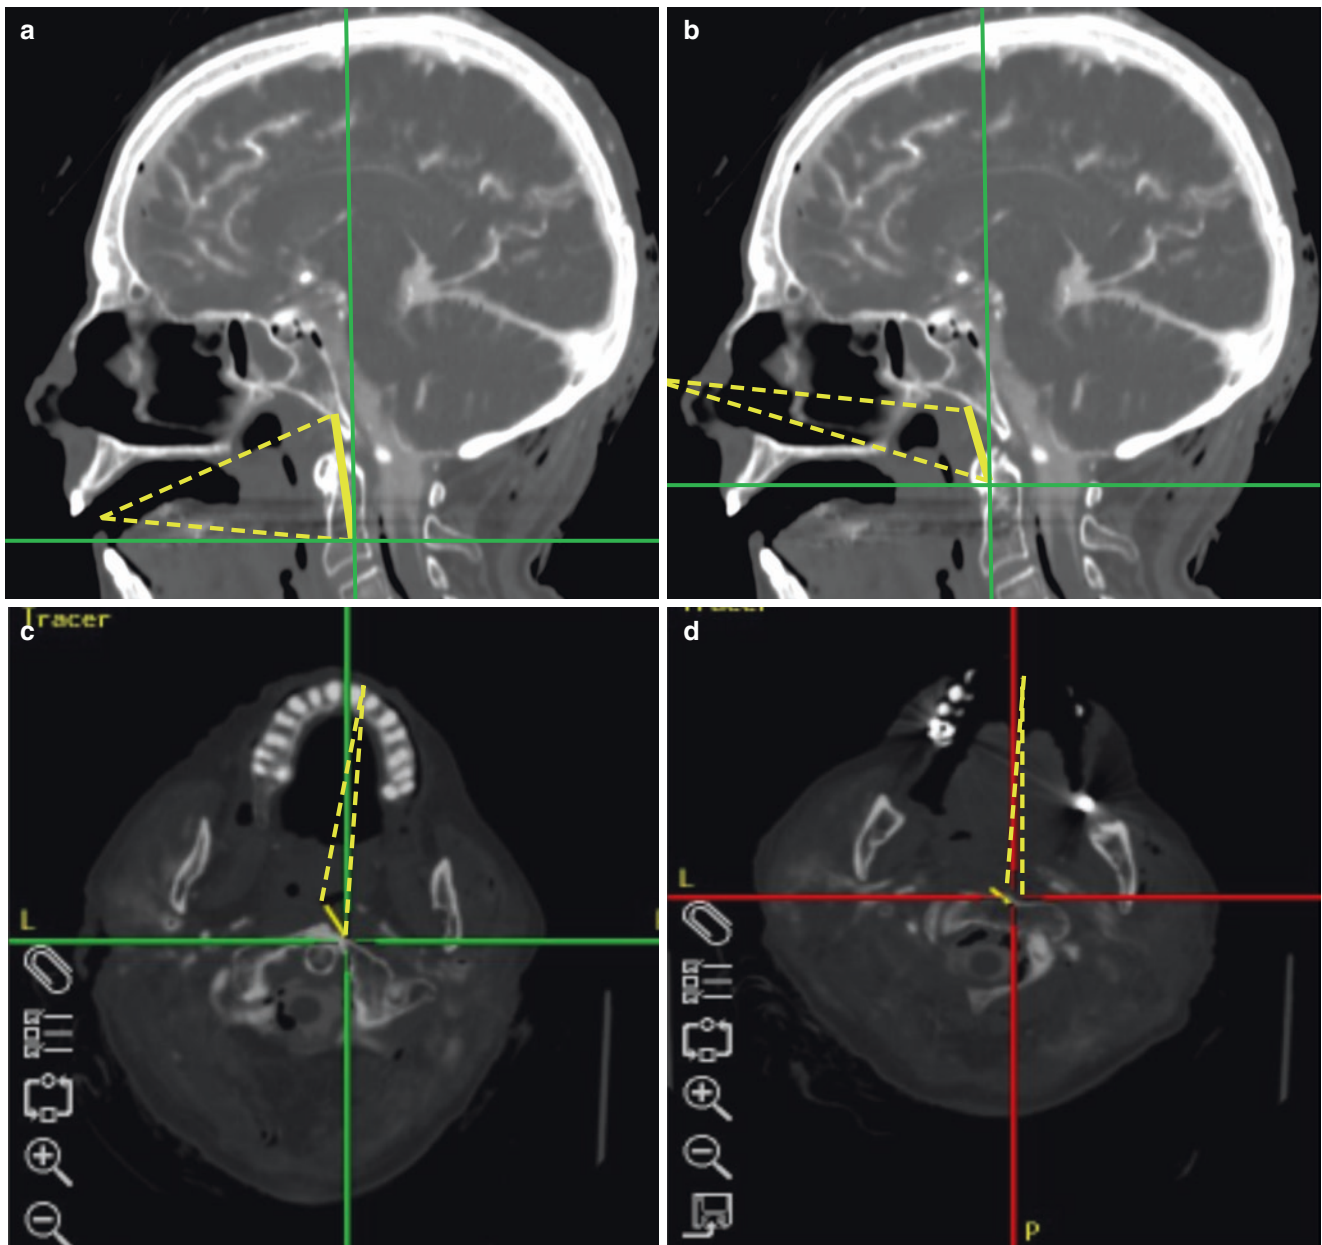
(a, b) Sagittal and (c, d) axial neuronavigated computed tomography (CT) scans with contrast medium showing (a) craniocaudal and (c) lateral exposures of the transoral approach and (b) craniocaudal and (d) lateral exposures of the transnasal approach
